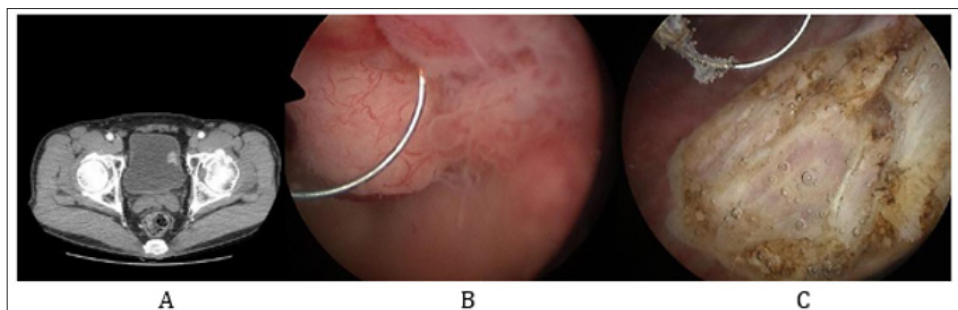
Initial bladder tumour at computed tomography and cystoscopy.
